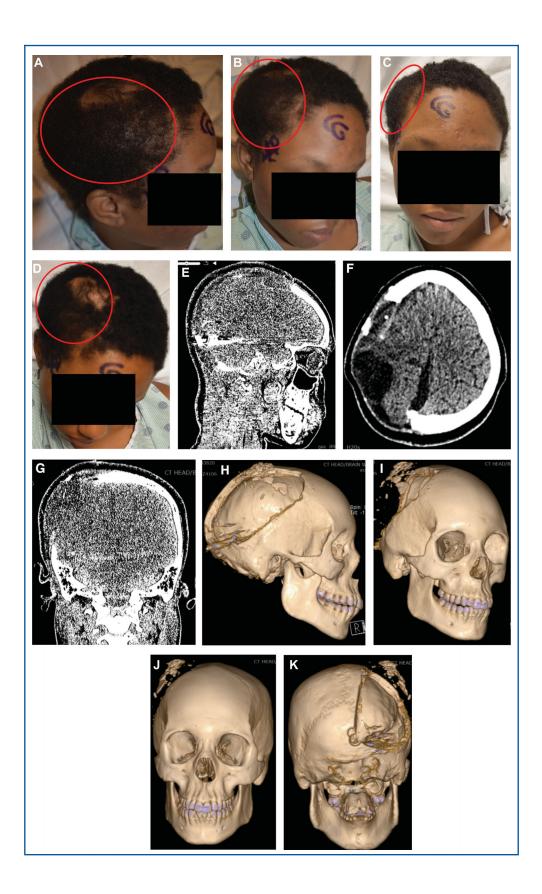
Preoperative photographs and radiographic imaging of the sentinel patient presenting for cranioplasty. A-D, Preoperative photographs of the patient in lateral, oblique, frontal, and bird's eye views. The red circle in each photograph denotes the area of brain herniation from the craniectomy defect. E-G, Representative CT scan images of the brain after decompressive hemicraniectomy and suboccipital craniectomy (sagittal, axial, and coronal views, respectively). Note the large hemicraniectomy defect, with cystic encephalomalacia within the herniated brain parenchyma, as well as subdural hygroma. Also note the extensive metallic debris from the retained bullet in the right occipital lobe and frontoparietal lobe. H-K, 3-D CT reconstruction imaging used for designing CCI. Note the hemicraniectomy defect, as well as the smaller suboccipital craniectomy defect visible from the posterior view K.
